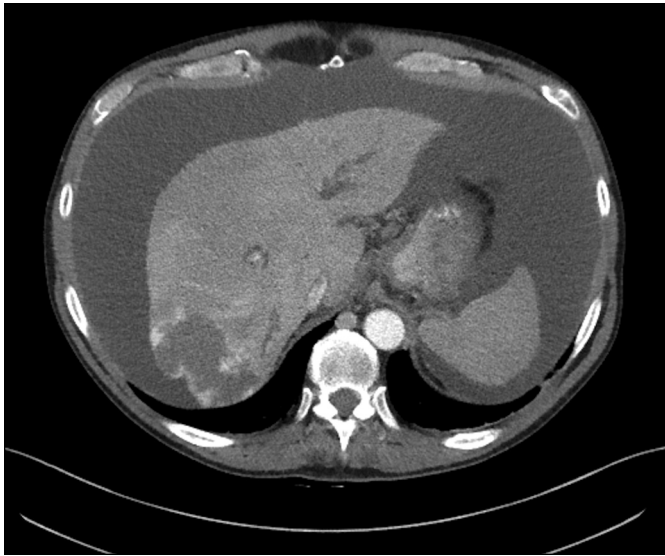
Abdominal computed tomography showing biliary ductal dilatation and a low-attenuation hepatic lesion ($3.7 \times 6.4 \times 5.1$ cm) in the right lobe, suggestive of hemangioma.
